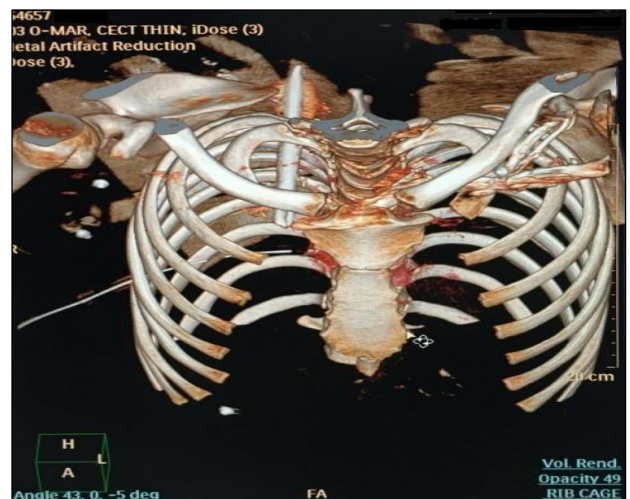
Volume rendered CT scan of the patient showing the location of the foreign body.
